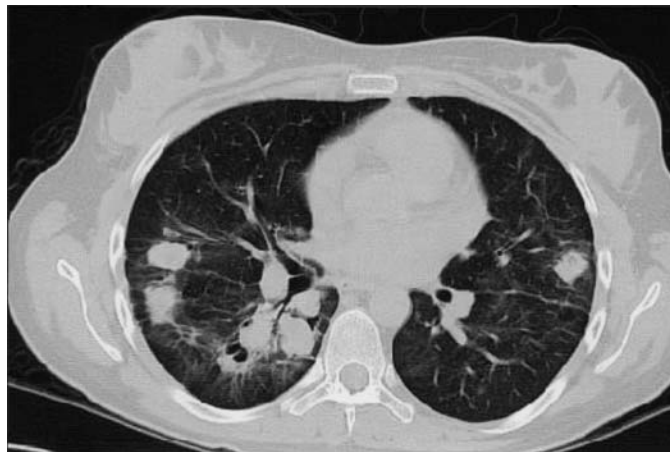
FIGURE e28-1 Bilateral nodular infiltrates seen on computed tomography of the chest in a 40-year-old woman with Wegener's granulomatosis.
